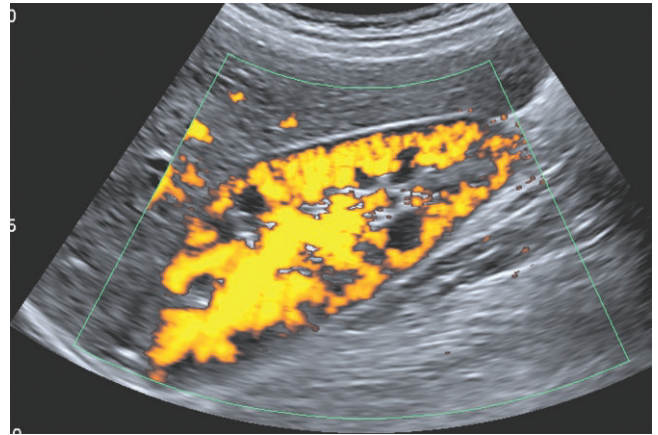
Power Doppler of the kidney with single color indicating power Doppler. There is no difference between arteries and veins. There is better filling of the slower flow in the cortex and at the poles. Power Doppler is not angle dependent like color Doppler. Slower flow can be detected because of better signal to noise compared with color Doppler.
